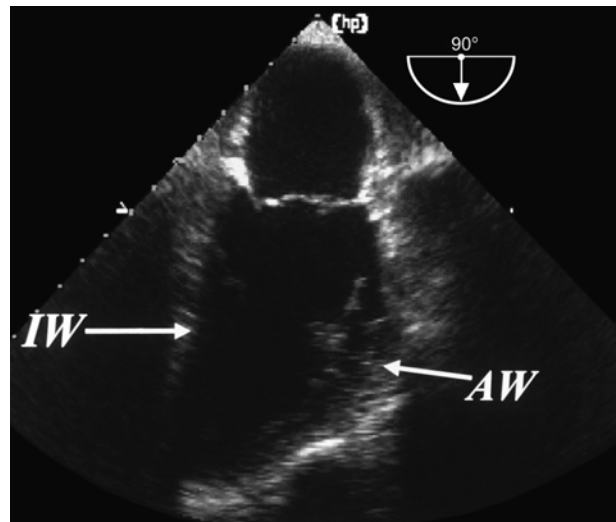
Transoesophageal two-chamber view.
